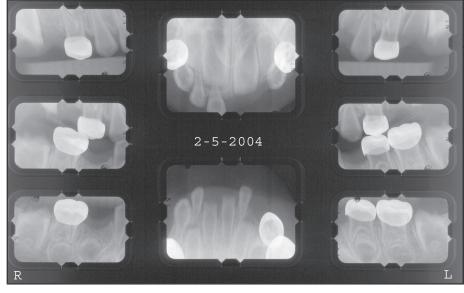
Intraoral periapical and bitewing radiographs of the patient after the second visit. Notice the placement of crowns on all erupted and clinically present primary molars.
